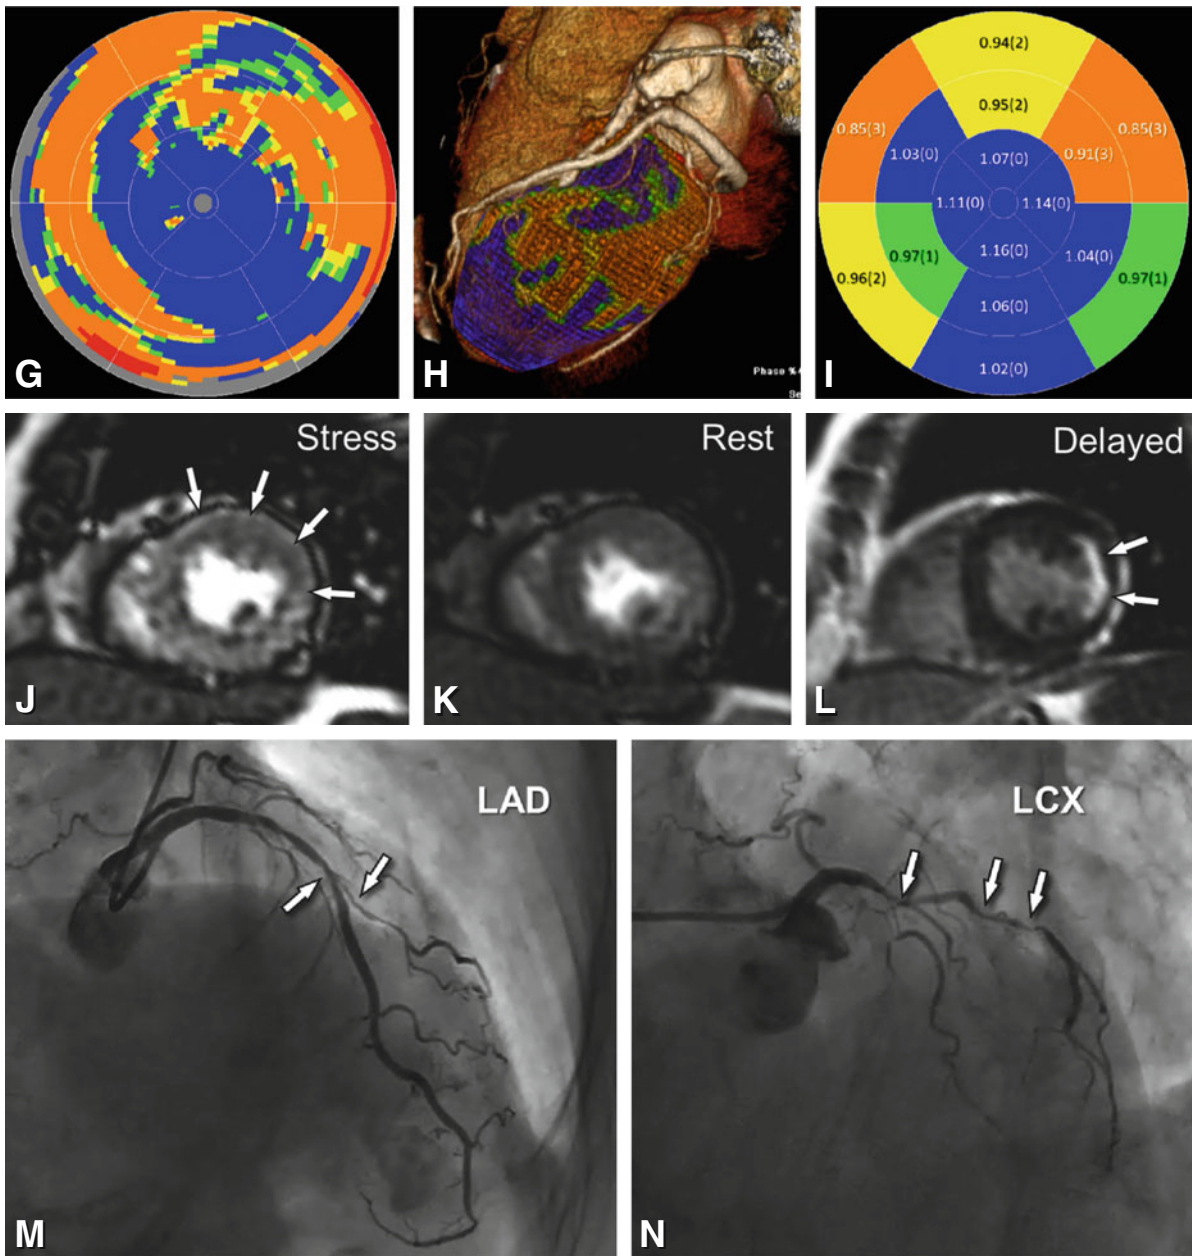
Comprehensive cardiac study using first-generation 320-row CT in a 78-year-old female with a history of lateral myocardial infarction and stent placement into the proximal right coronary artery 6 months earlier. Resting coronary CTA demonstrates a patent right coronary artery stent (Panel A). The left anterior descending (LAD) coronary artery was not evaluable due to heavy calcifications (Panels B and C) and there was a diffuse severe stenosis in the left circumflex (LCX) coronary artery (Panel D). Static (single-shot) stress CTP demonstrated a perfusion deficit in the anterior wall and lateral wall (arrows in Panel E), which was not evident on rest CTP (Panel F)
